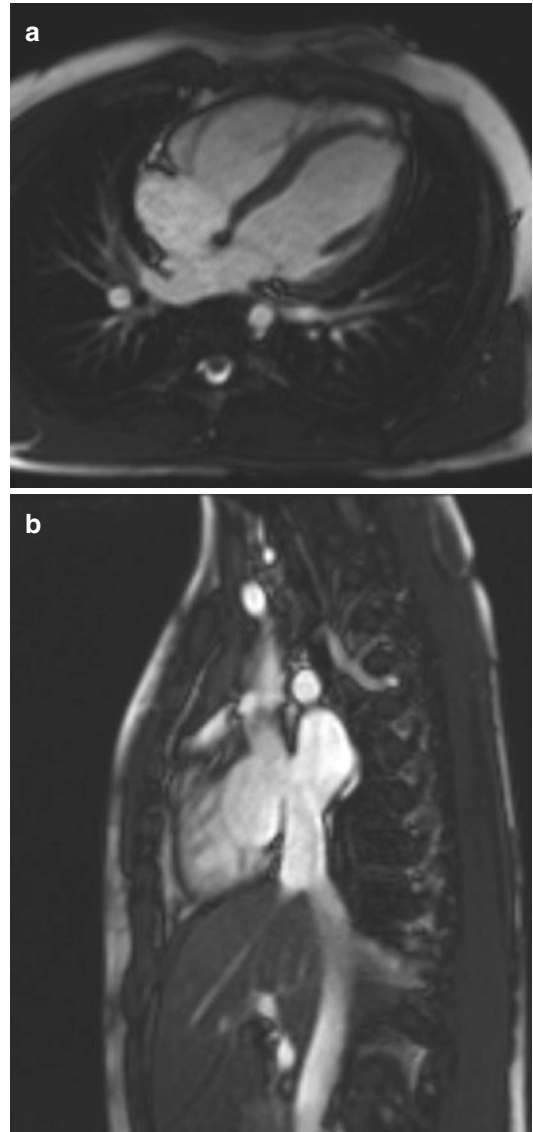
Secundum ASD. (a) Four-chamber view and (b) perpendicular view of the interatrial septum images obtained from cine TRUFISP MRI sequence demonstrate an isolated, high-riding ostium secundum defect. The QP/QS ratio was estimated to be 1.4:1
